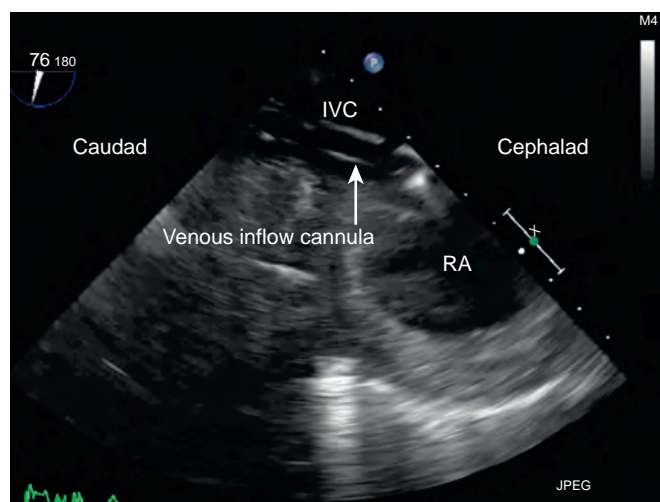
Transesophageal echocardiographic image of the venoarterial extracorporeal membrane oxygenation inflow cannula within the junction of the inferior vena cava (IVC) and the right atrium (RA). Caudad and cephalad directions are marked on the image for orientation. The cannula (which has been inserted percutaneous from the right common femoral vein) tip sits within the RA, and the cannula contains side fenestrations to increase inflow volume. The cannula has been advanced into the superior vena cava (not pictured) under echocardiographic guidance to improve upper body venous drainage. (Courtesy K. Ghadimi, MD.)
